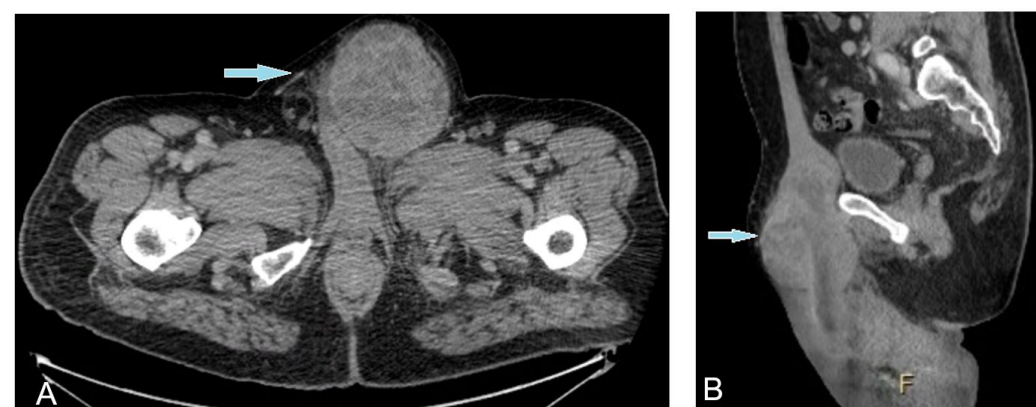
Transverse (A) and sagittal (B) views on CT abdomen and pelvis at emergency visit documenting tumor herniation with significant mass effect and inflammatory changes.
